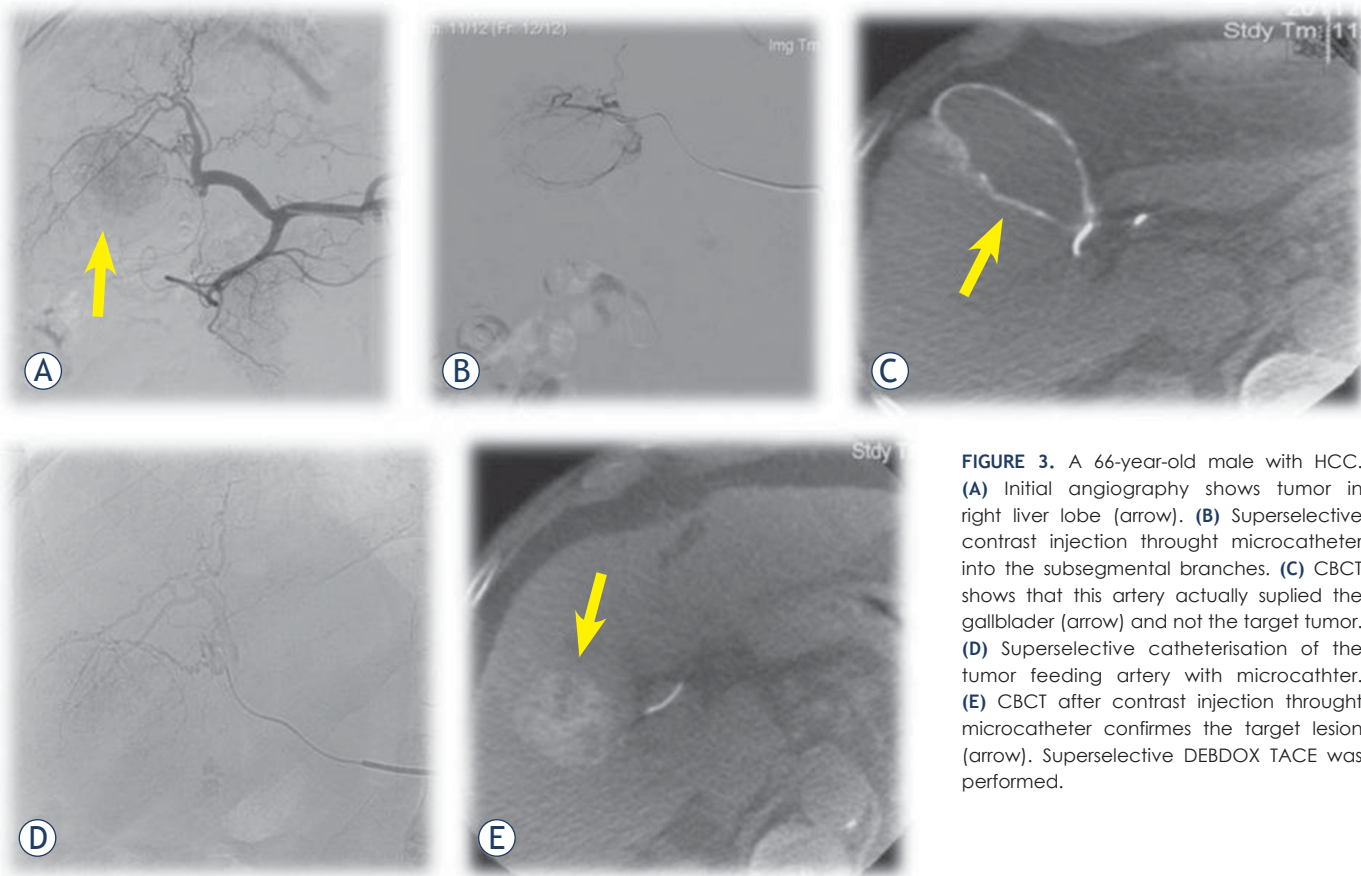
A 66-year-old male with HCC. (A) Initial angiography shows tumor in right liver lobe (arrow). (B) Superselective contrast injection through microcatheter into the subsegmental branches. (C) CBCT shows that this artery actually supplied the gallbladder (arrow) and not the target tumor. (D) Superselective catheterisation of the tumor feeding artery with microcatheter. (E) CBCT after contrast injection through microcatheter confirms the target lesion (arrow). Superselective DEBDOX TACE was performed.
